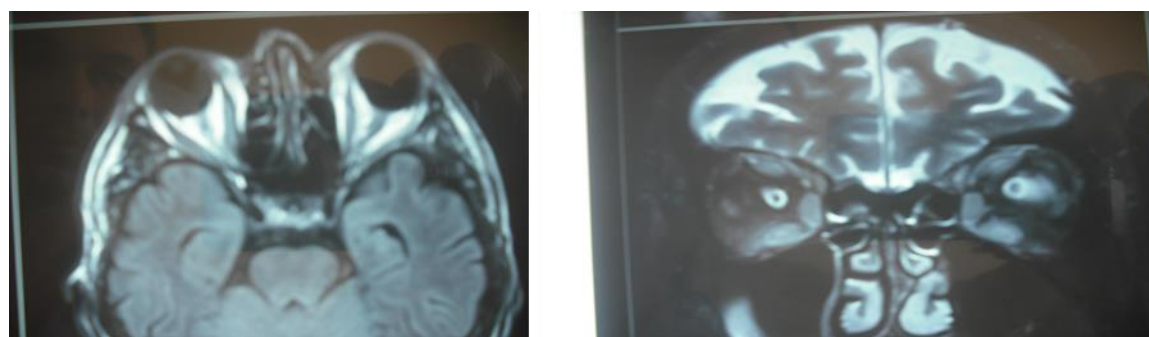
The orbit MRI revealed enlargement of the inferior, medial, and superior recti muscles.
